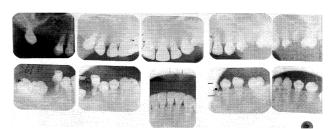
Radiographs of Case 2.
